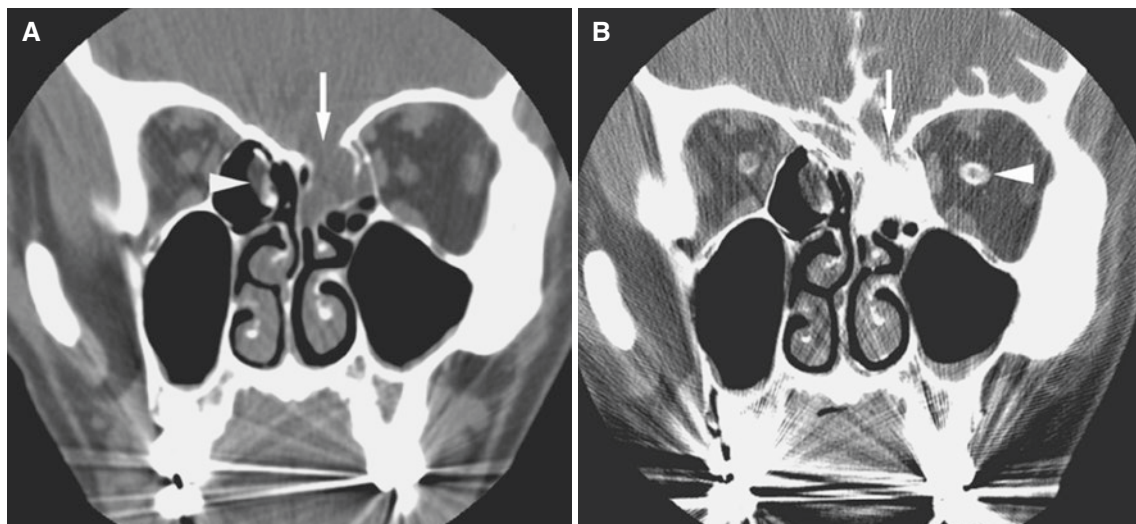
Leakage of CSF; 28-year-old male with history of gunshot wound to vertex a few years ago with multiple fractures including the left maxilla, orbital floor, lamina papyracea, and left cribriform plate, the latter surgically repaired on the right aspect. Clinical course complicated by bacterial meningitis, now referred for CT cisternography to locate continued rhinorrhea. (A) Coronal CT image shows defect of the left cribriform plate and lamina papyracea with opacification of the left
